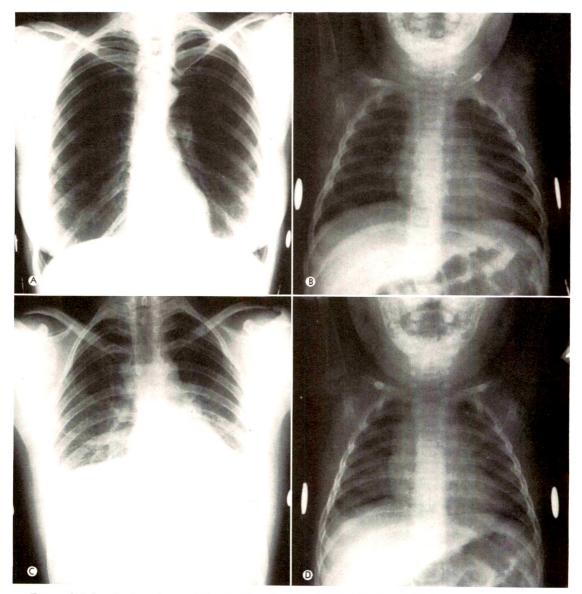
(A) Inspiration chest roentgenogram of adult. (B) Inspiration chest roentgenogram of child. (C) Expiration chest roentgenogram of adult. (D) Expiration chest roentgenogram of child.
